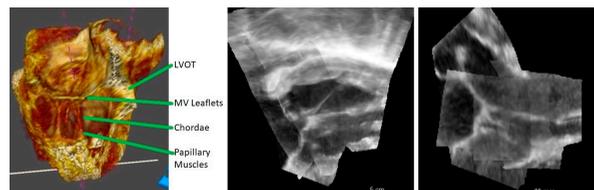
Side-by-side volume rendered comparisons from multiple view points of the CT data (top) and compounded echo (bottom).
